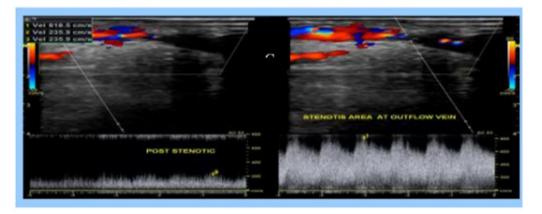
Significant Juxta-anastomotic stenosis of right radio-cephalic fistula of Female patient 16 years old had right radio-cephalic fistula. (a) cephalic vein which show diameter reduction $<50\,\%$ with distance about 2 cm from the anastomosis at (juxta- anastomotic area) and measures about 1.6 mm at the narrowest area . (b) Focal aliasing and visible colour bruit artifact at juxta anastomotic area (the most common stenotic area) (c) Doppler study reveals monophasic low resistant flow with markedly elevated velocity measure 820 cm/s at stenotic area while post stenotic velocity measure 235 cm/s having a velocity ratio.
